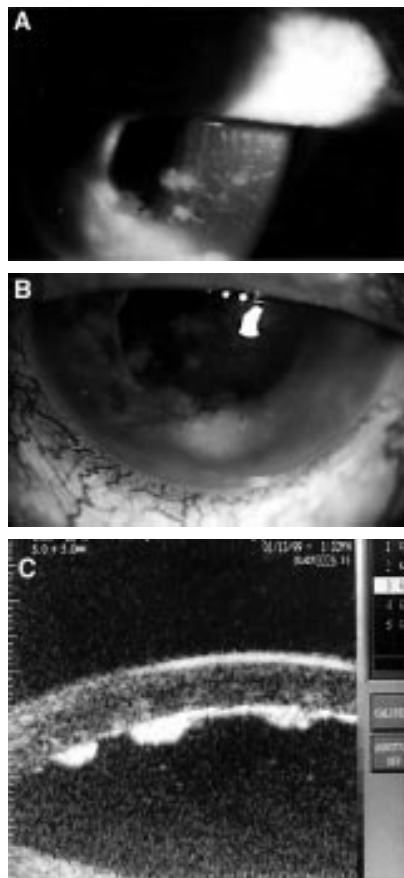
Slit lamp examination of the left eye revealed yellow-white keratic precipitates on the cornea, 4+ cells in the anterior chamber (A); clumps of similarly coloured debris on iris with neovascularisation (B). On high frequency ultrasonography, deposits on the corneal endothelium, diffuse iris thickening, and a nodular thickening on the inferior quadrants of the ciliary body were observed (C).
